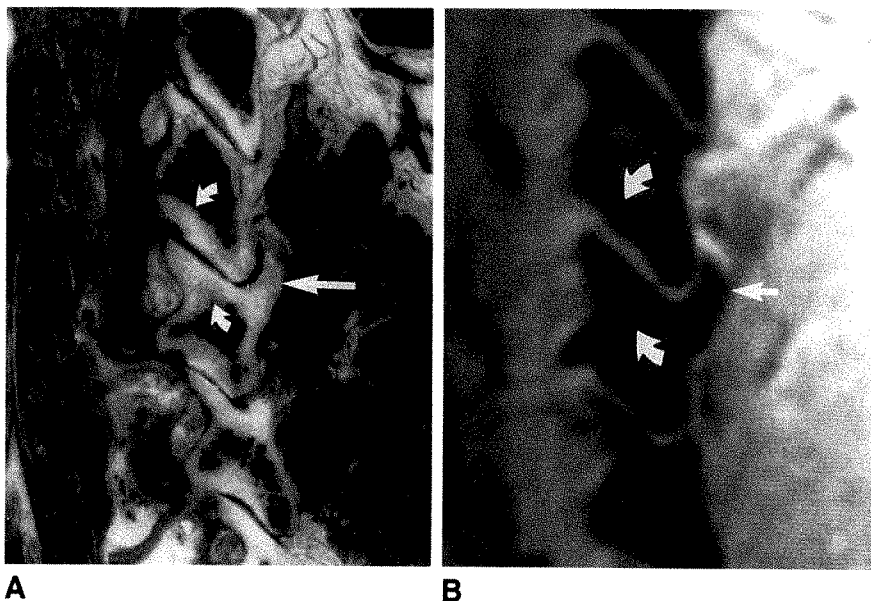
A and B, Anatomic section (A) and MR image (B) show degenerated C3–C4 facet joint with thinned articular cartilage, thickened articular cortical bone (curved arrows), and an osteophyte (straight arrow). Osseous changes are shown effectively in MR image (B). None of the facet joints have evident cartilage or regular cortical bone on the anatomic sections.
